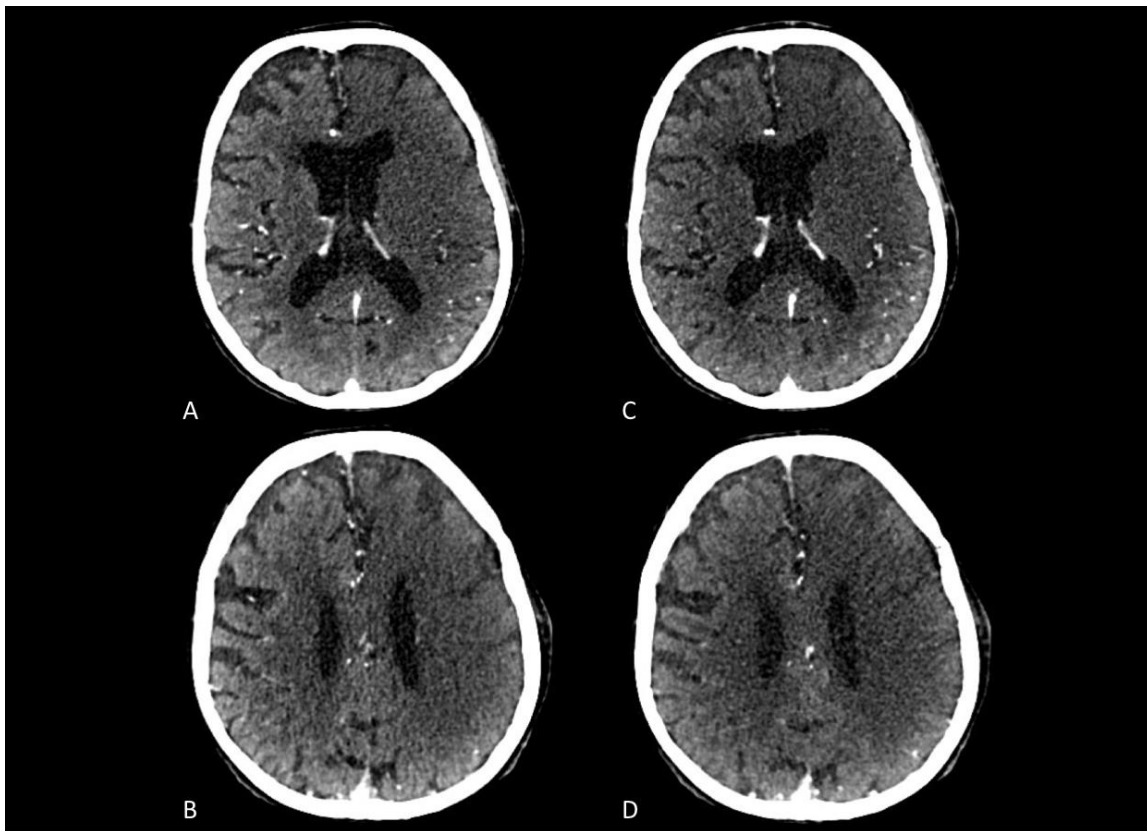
Occlusion in M1 segment of the left middle cerebral artery. A & B) In arterial phase with low CTA-SI ASPECTS, C & D) In delayed phase without significant changes.
